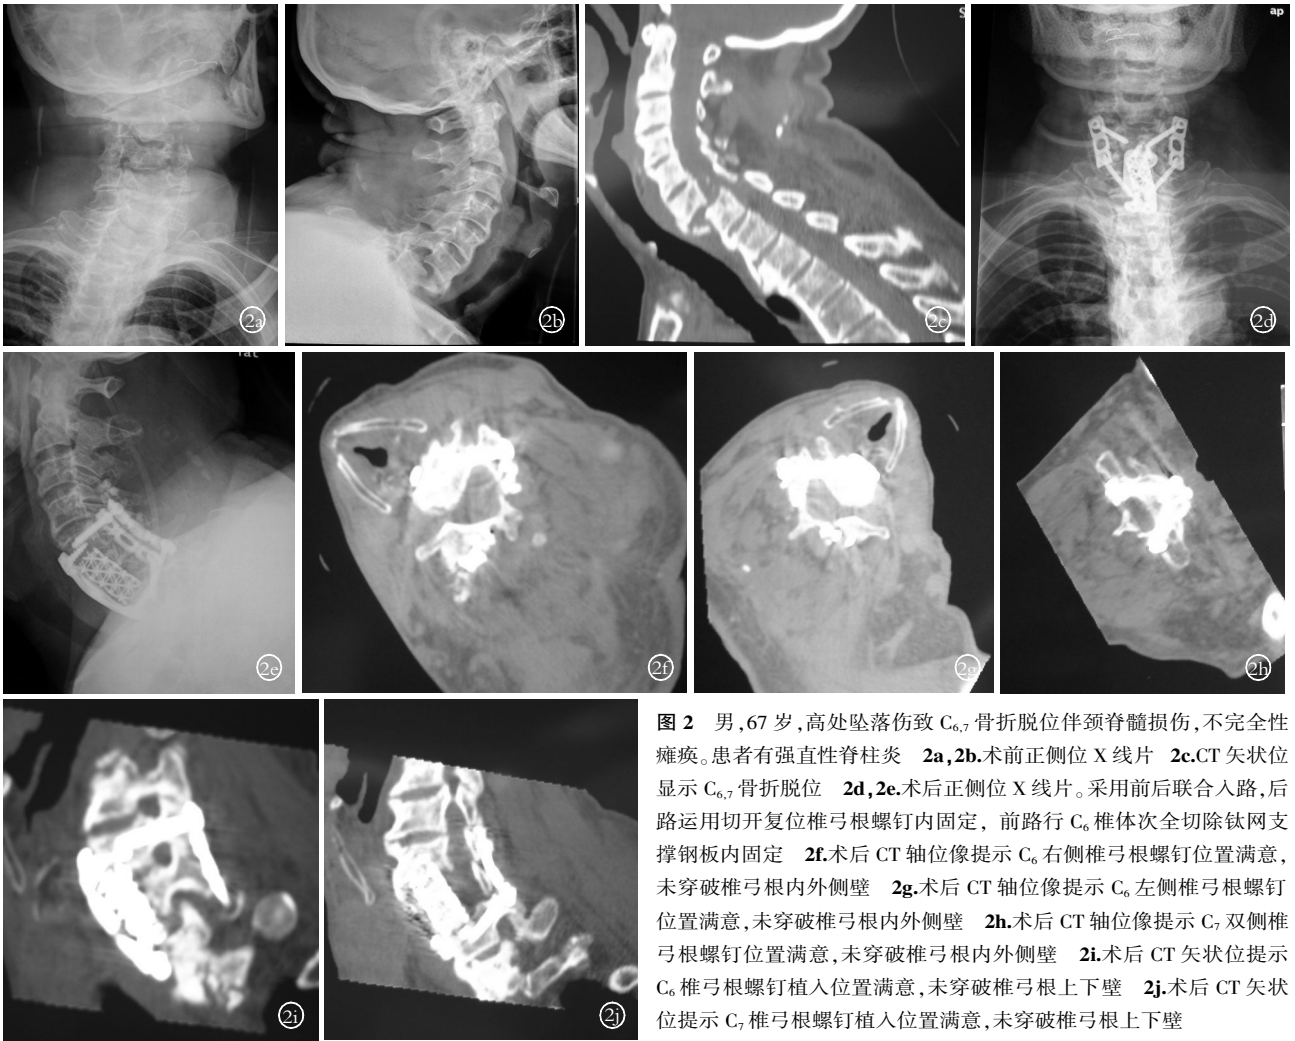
男,67 岁,高处坠落伤致 C_{6,7} 骨折脱位伴颈脊髓损伤,不完全性瘫痪。患者有强直性脊柱炎 2a,2b.术前正侧位 X 线片 2c.CT 矢状位显示 C_{6,7} 骨折脱位 2d,2e.术后正侧位 X 线片。采用前后联合入路,后路运用切开复位椎弓根螺钉内固定,前路行 C₆ 椎体次全切除钛网支撑钢板内固定 2f.术后 CT 轴位像提示 C₆ 右侧椎弓根螺钉位置满意,未突破椎弓根内外侧壁 2g.术后 CT 轴位像提示 C₆ 左侧椎弓根螺钉位置满意,未突破椎弓根内外侧壁 2h.术后 CT 轴位像提示 C₇ 双侧椎弓根螺钉位置满意,未突破椎弓根内外侧壁 2i.术后 CT 矢状位提示 C₆ 椎弓根螺钉植入位置满意,未突破椎弓根上下壁 2j.术后 CT 矢状位提示 C₇ 椎弓根螺钉植入位置满意,未突破椎弓根上下壁
